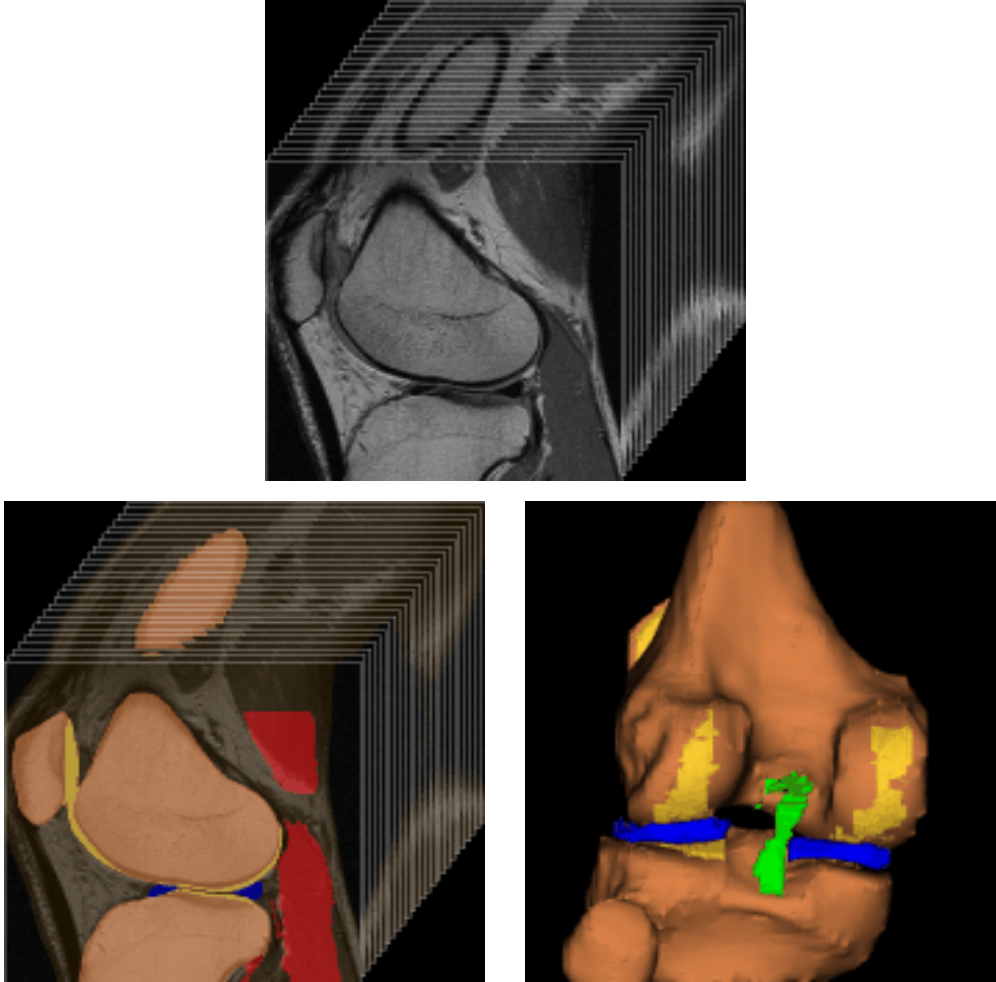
Top: A stack of 2D cross-sectional slices comprising a 3D knee MRI scan. Bottom Left: Segmentation as a stack of 2D slices showing bones, cartilage, and ligaments. Bottom Right: A 3D rendering of the individual structures in the segmented image.
